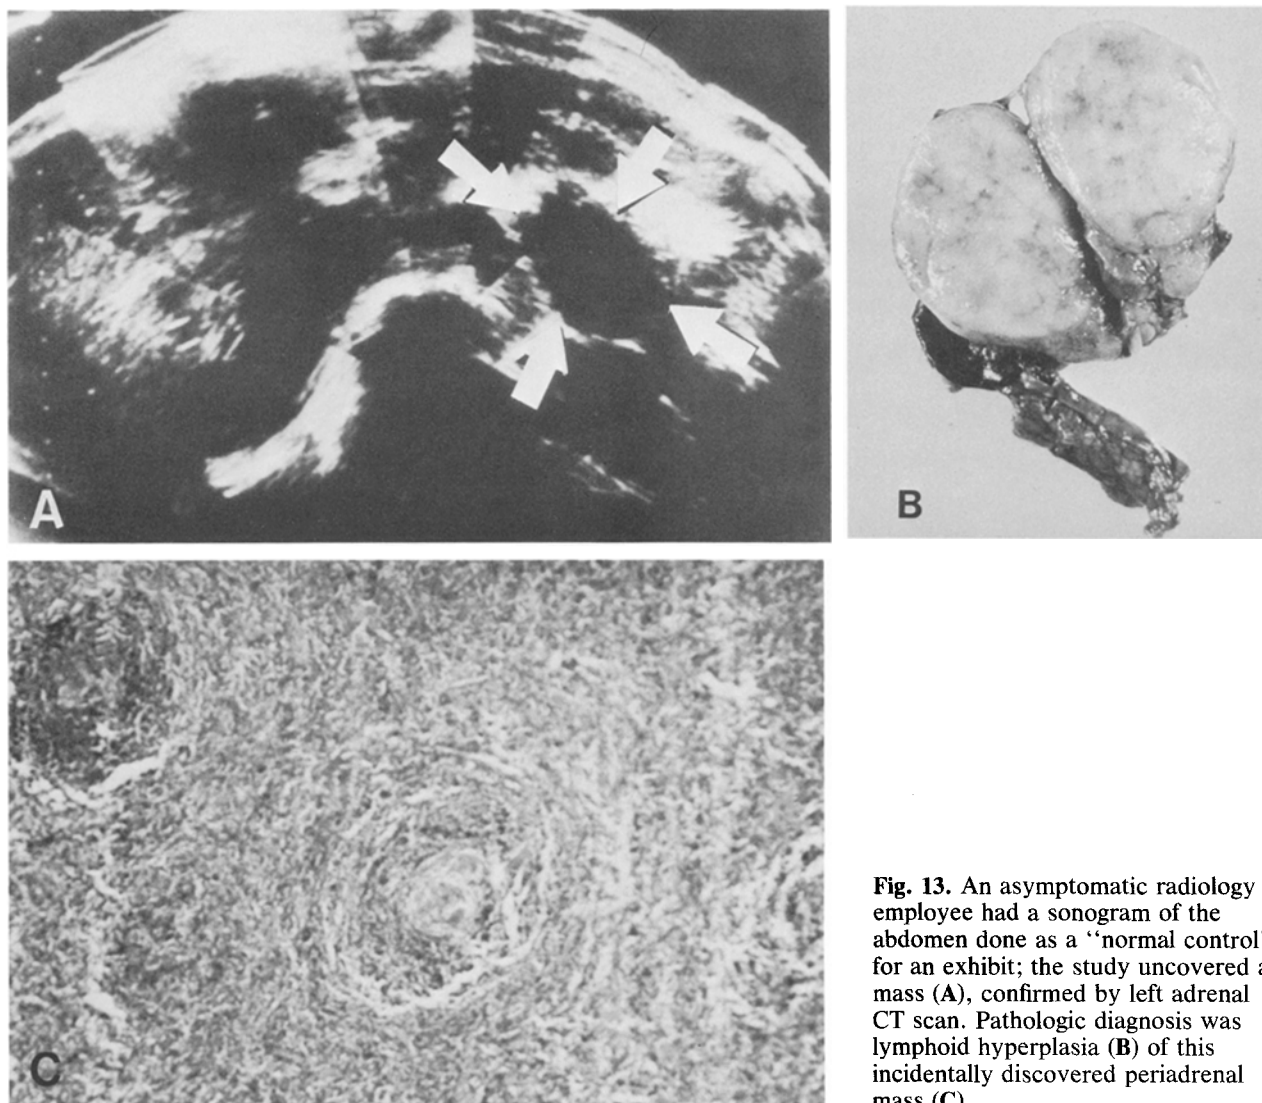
An asymptomatic radiology employee had a sonogram of the abdomen done as a "normal control" for an exhibit; the study uncovered a mass (A), confirmed by left adrenal CT scan. Pathologic diagnosis was lymphoid hyperplasia (B) of this incidentally discovered periadrenal mass (C).
